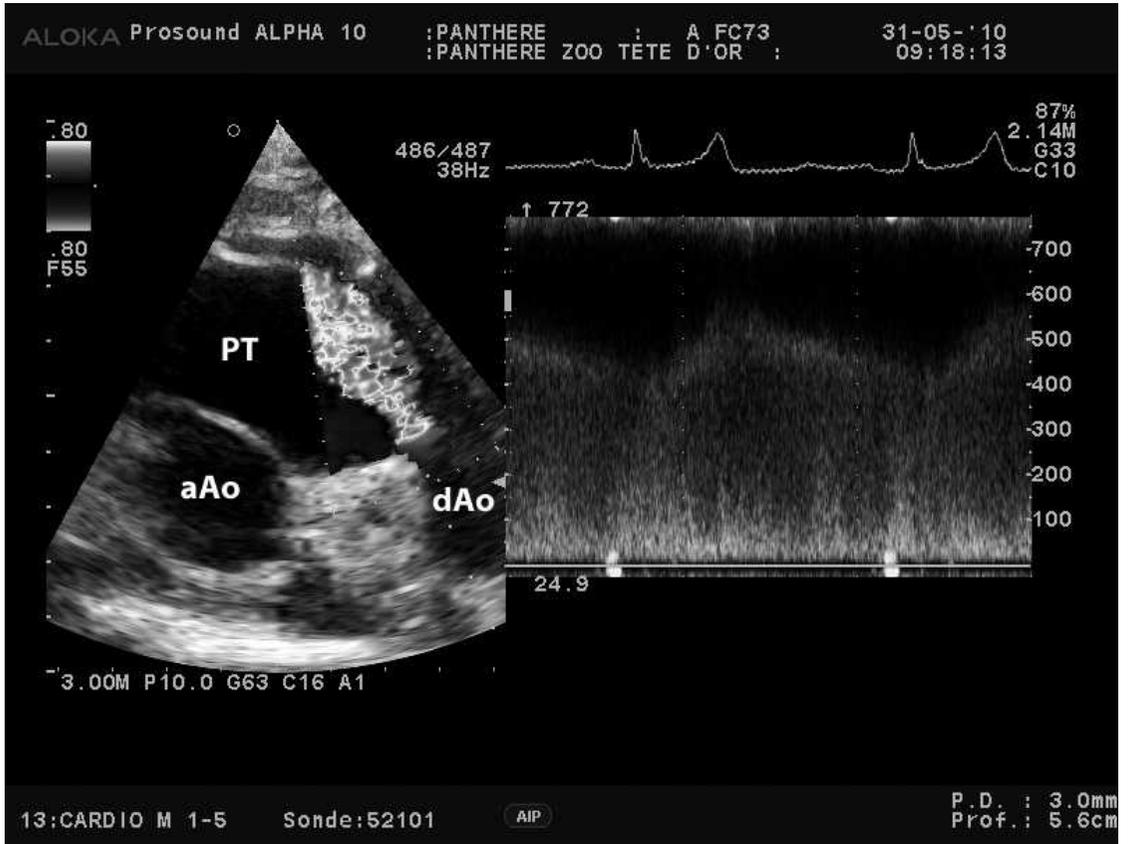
Echocardiographic image from a left parasternal window (modified short-axis view). The picture on the left side (two-dimensional mode) shows a turbulent flow in the pulmonary trunk starting at the level of the orifice of the patent ductus arteriosus on the pulmonary trunk side (left-to-right shunting). The picture on the right (continuous Doppler) shows the very high-velocity continuous flow coming from the PDA (speed scale in cm/sec on the right side). (PT) pulmonary trunk, (aAo) ascending aorta, (dAo) descending aorta.
